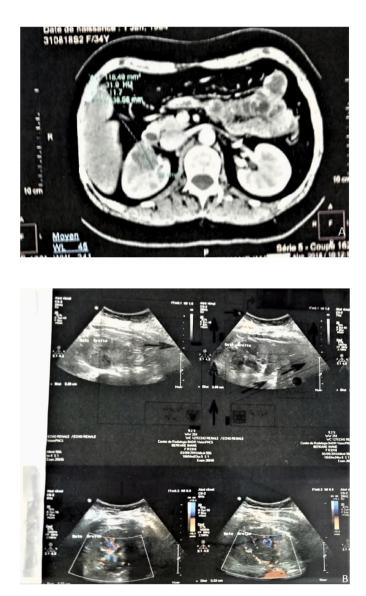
Two tumor-like lesions in the right kidney (A) A doppler ultrasound: two lesions, tissue, heterogenous, hypoechogenic and hypo vascular (B).
